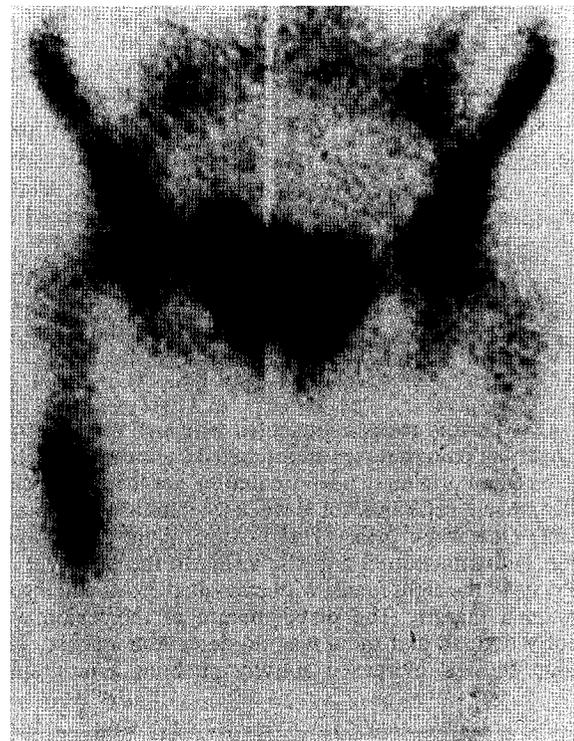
Technetium-99m bone scintigram demonstrates a focal region of increased radiopharmaceutical uptake in the right proximal femur corresponding to the radiographic abnormality. No other abnormalities are noted.
